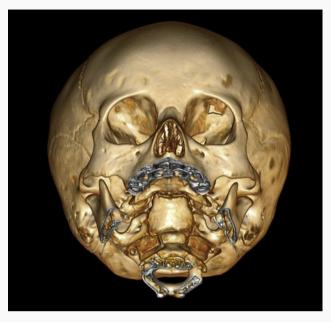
Three-dimensional reconstructed CT imaging showing orbital roof defect.
